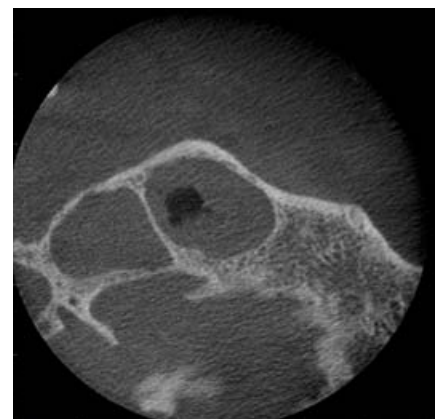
Axial CBCT image
